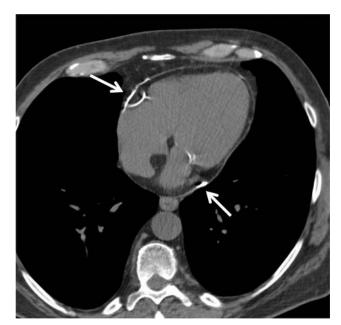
Nongated unenhanced cardiac CT demonstrates only minimal thickening of the pericardium up to 3 mm but presence of linear pericardial calcification (*white arrows*) over the right and left atrioventricular grooves suggestive of prior pericardial process.
